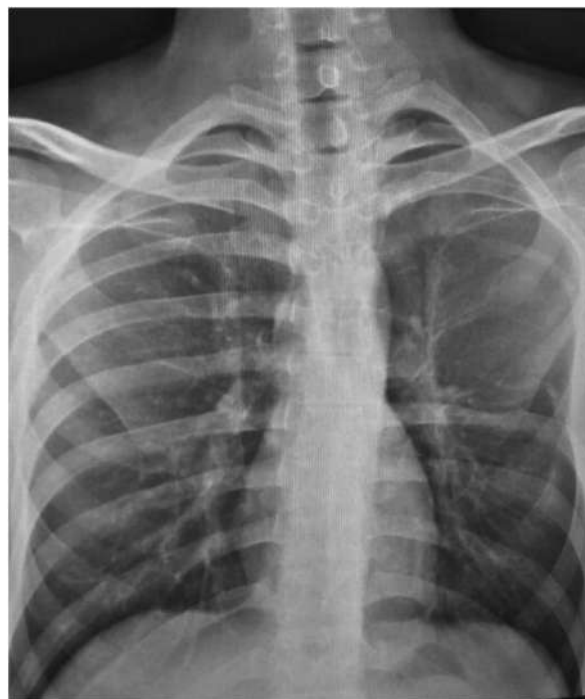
Chest x-ray showed that the fourth to sixth ribs were missing in the left hemithorax.
